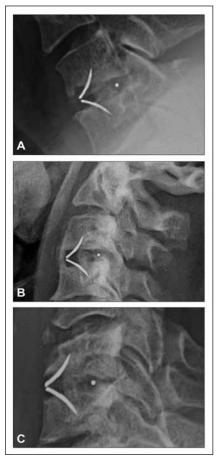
A, Lateral cervical radiograph 3 months after surgery shows persisting autograft bone within lumen of ROI-C cervical cage (LDR) and early osseous bridging anterior to device. B, Lateral cervical radiograph 3 months after surgery shows persisting autograft bone within lumen of ROI-C cervical cage and complete osseous bridging anterior to device. C, Lateral cervical radiograph 4 months after surgery shows persisting bridging bone within lumen of device and little anterior ossification.
